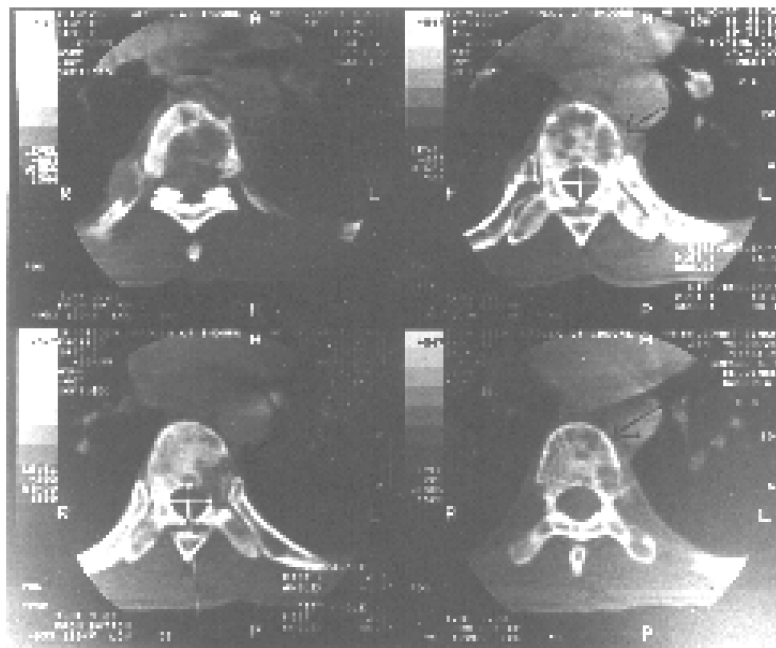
CT Scan showing multiple osteolytic area in vertebral bodies
